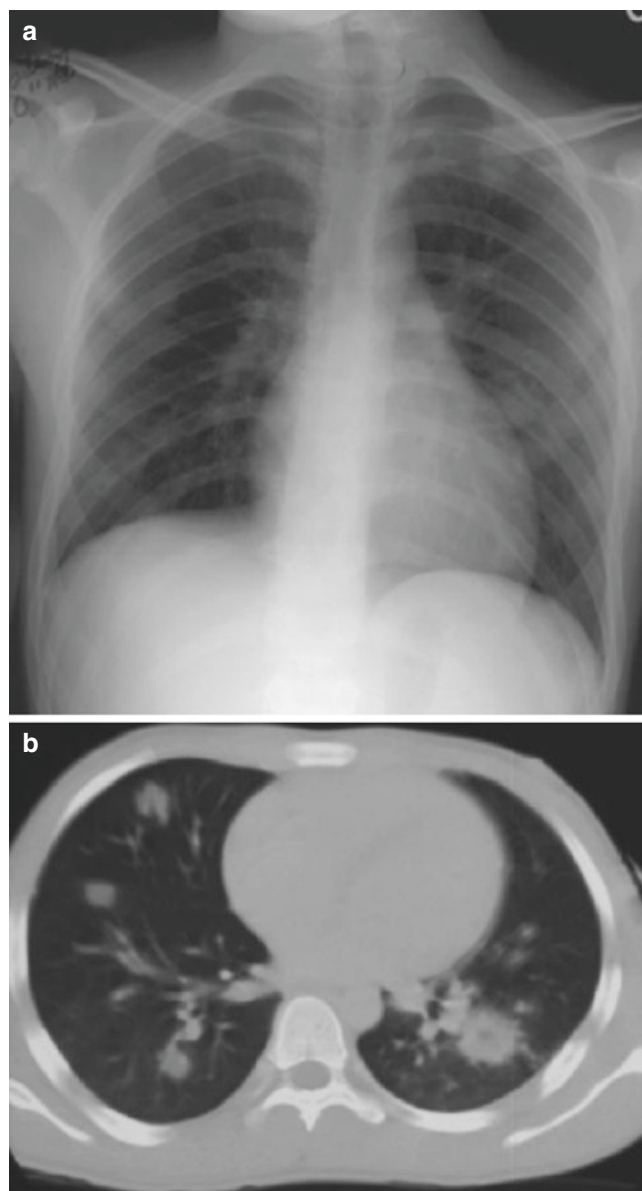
A 7-year-old boy with thrombophlebitis of the internal jugular vein with septic emboli. (a) Frontal chest radiograph and (b) axial lung window CT image show ill-defined bilateral pulmonary opacities on chest radiograph, which are better visualized on CT. On CT, there is cavitation of the left posterior pulmonary nodule. These pulmonary nodules are most consistent with septic emboli
